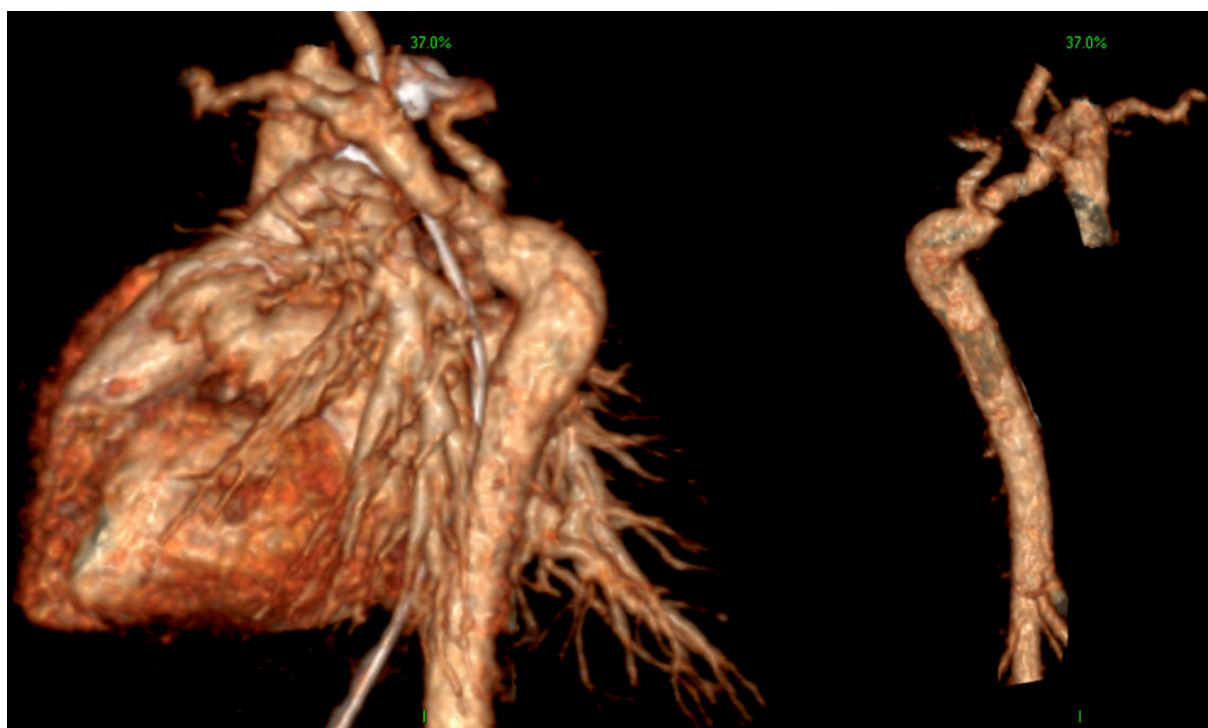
Computed tomography scan demonstrating (left) the left lateral view demonstrating a circumflex aorta with left aortic arch; and (right) anterior view of the same patient showing a circumflex aorta with left aortic arch and hypoplastic arch segment
